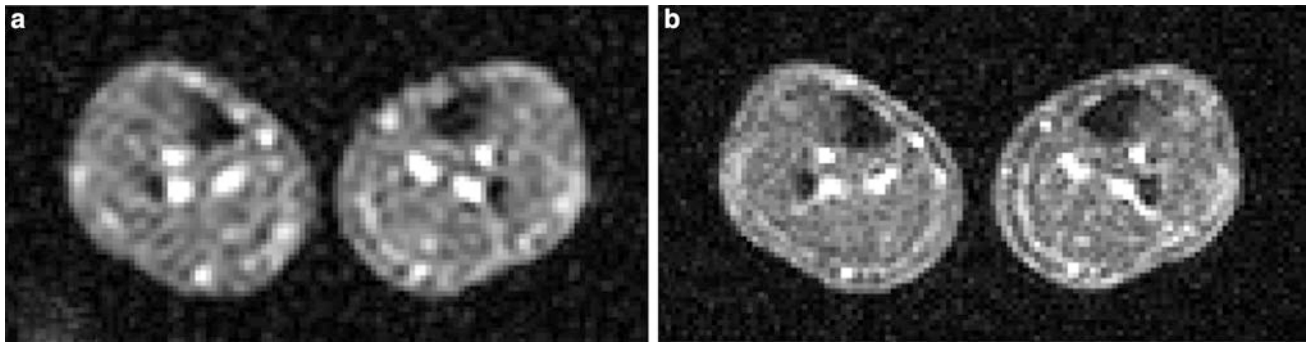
^{23}Na MR image of the human calf muscle. For both acquisitions (a, b) the same measurement times were used (13 min 54 s). a Isotropic nominal spatial resolution (5.1 mm^3). b The
